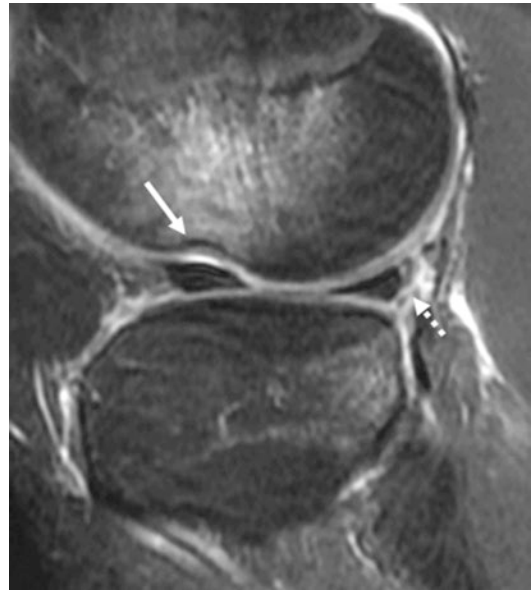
Sagittal T2-weighted fat-suppressed image from a 15-year-old boy shows hyperintense signal within bone marrow consistent with pivot shift bone contusions in the anterior central lateral femoral condyle and posterior lateral tibial condyle. In addition there is a subchondral bone depression related to impaction fracture in the lateral femoral condyle (*arrow*) and lateral meniscal tear (*dashed arrow*)
